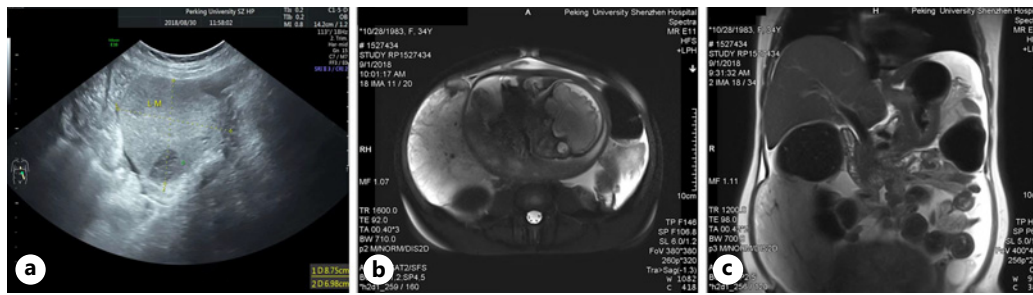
Preoperative images of case 2. a Ultrasonography revealed a solid, heterogeneous mass in the left adnexal area, which was approximately 9 cm × 7 cm in size, with clear boundaries. MRI examination was performed, which showed diffuse gastric wall thickening and stiffness (c). Bilateral mass images (b), with an equal T1 long T2 signal shadow, uniform, contained multibarreled shadows, with sizes of 17 cm × 15 cm × 11 cm (right) and 8 cm × 7 cm × 4 cm (left). MRI, magnetic resonance imaging.
